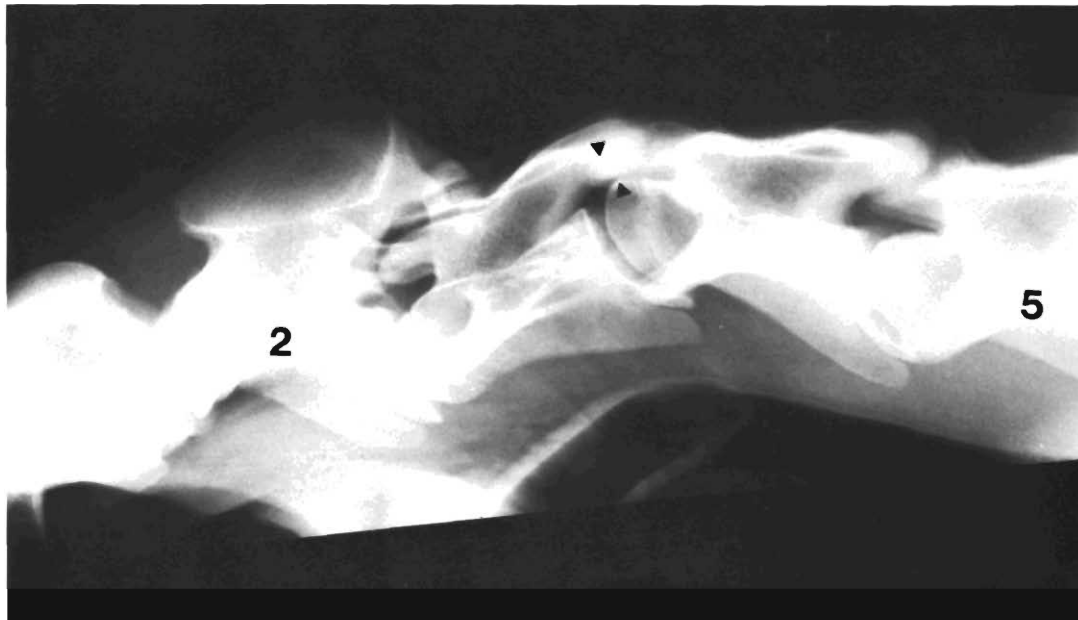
This is a survey radiograph of the cervical spine with the head flexed. The structural changes of the caudal part of the body of C-3 can be seen by comparing C-4. The marked narrowing of the neural canal at the C3-4 junction (arrow-heads) secondary to the vertebral instability is seen.
